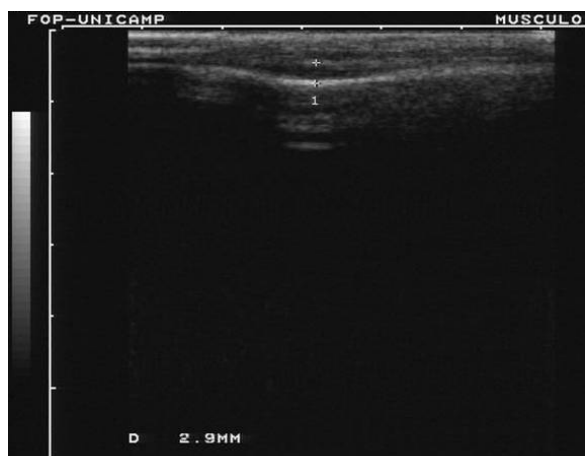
Caso clínico 1: imagem ultrasonográfica da porção anterior do músculo temporal (lado direito) em repouso (fase 3).
